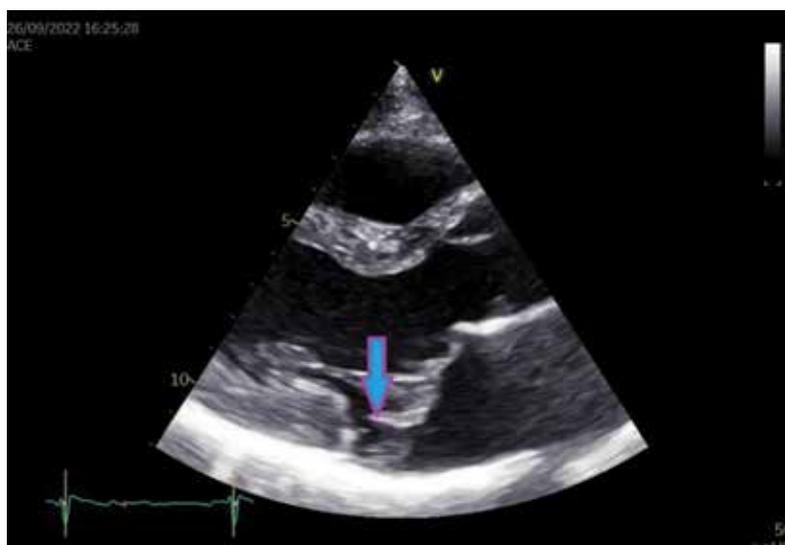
TTE parasternal long axis demonstrating scallop billowing and mitral annular disjunction (blue arrow).
